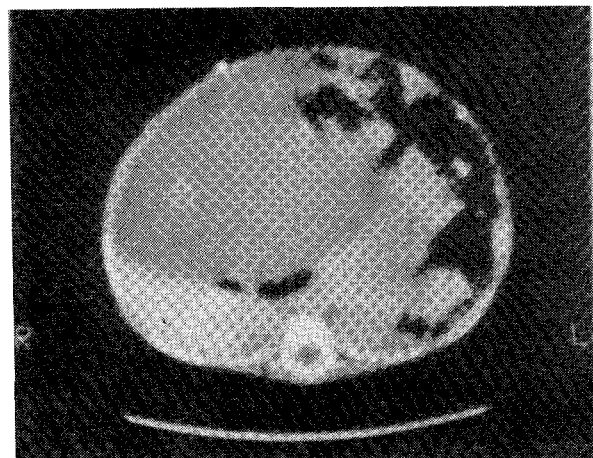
Abdominal CT scan showing the distended abdomen with CSF displacing the bowel to the left. Hounsfield units of CT measurements: (1) Liver 73.5 SD = 5.4(2) CSF 17.9 SD = 4.6
